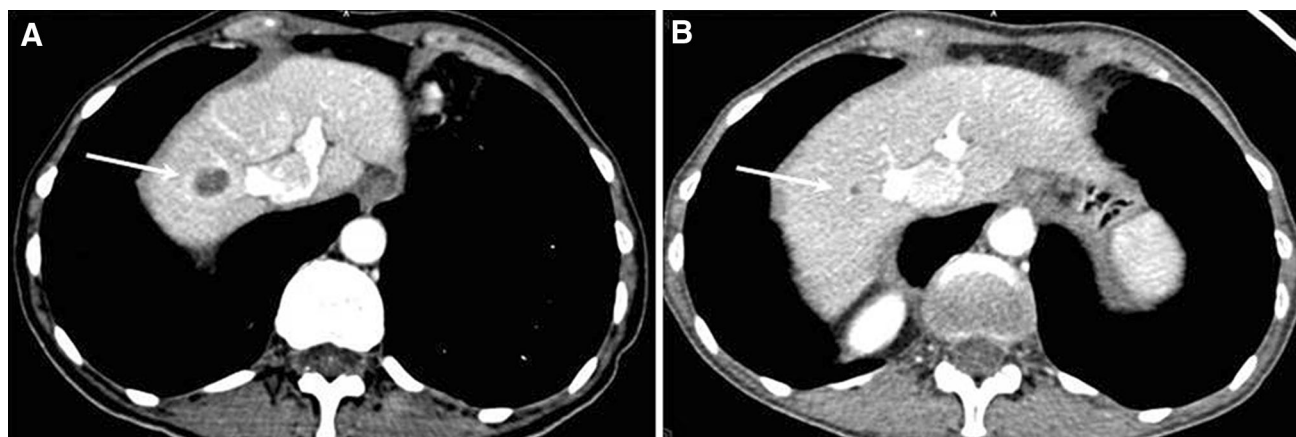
a Colorectal cancer metastasis measuring 14 mm in the dome of the liver following anti-EGFR therapy. b Repeat scan showing over 30 % reduction in metastasis diameter and partial radiological response at 12 weeks. Intraoperative ultrasound detected a single
